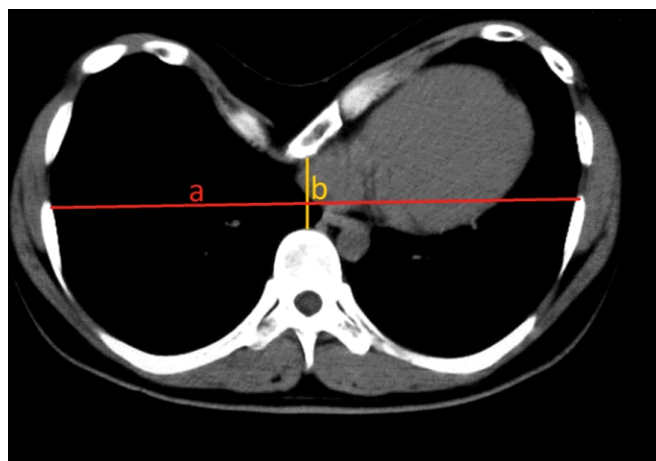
A computed tomography showing the calculation of Haller index (a/b)
